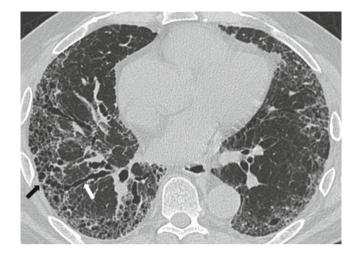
Transverse HRCT image that is diagnostic of idiopathic UIP (IPF) in the appropriate clinical setting with reticular lines, subpleural honeycomb change (*black arrow*), and traction bronchiectasis (*white arrow*)
